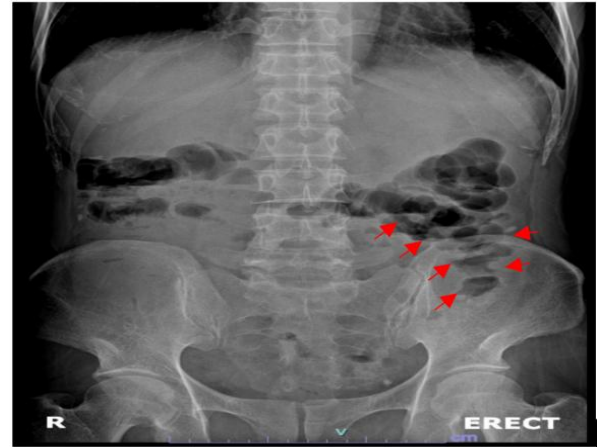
Abdominal upright/supine radiographic image of the patient noted with "thumb print" sign (red arrow heads)
